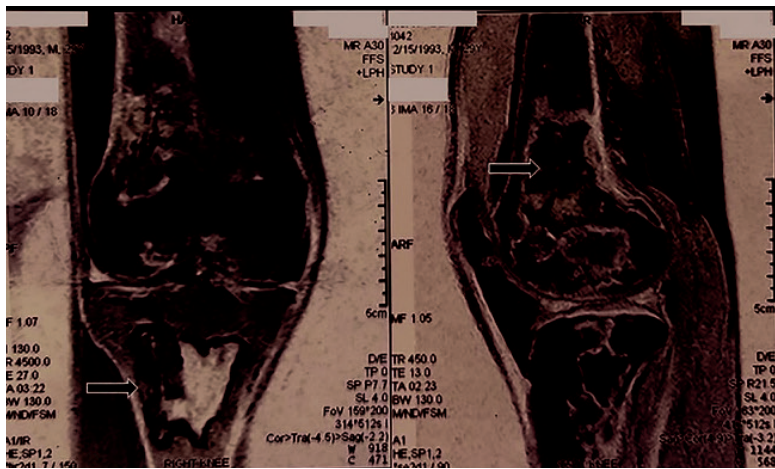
Magnetic resonance imaging of the right knee showed multiple medullary meta-diaphyseal lesions in the proximal tibia and distal femur with serpiginous border and the classical double line sign (white arrows) and subchondral necrosis of condyles.
